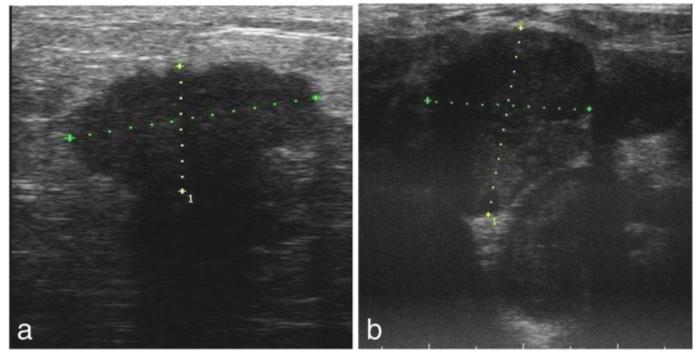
Ultrasound of the right breast and b right axilla in 40 years old women shows a a unifocal mass with irregular shape, spiculated margin, echogenic halo with non-parallel orientation, and posterior shadowing; it measures 15×9 mm. b Multiple malignant featuring right axillary lymph nodes. The mass proved pathologically to be low grade invasive ductal carcinoma with malignant infiltration of the LN and luminal B subtype. (52)
